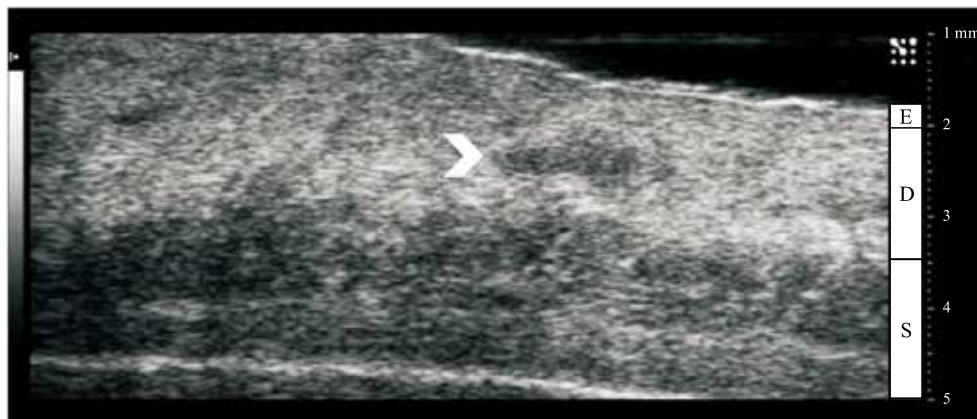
High resolution ultrasound performed at 70 MHz details the layers of the skin. From superficial to deep, the epidermis (E), dermis (D), and subcutaneous layer (S) is appreciated. An unnamed compressible vein within the dermis is indicated by an arrowhead.
